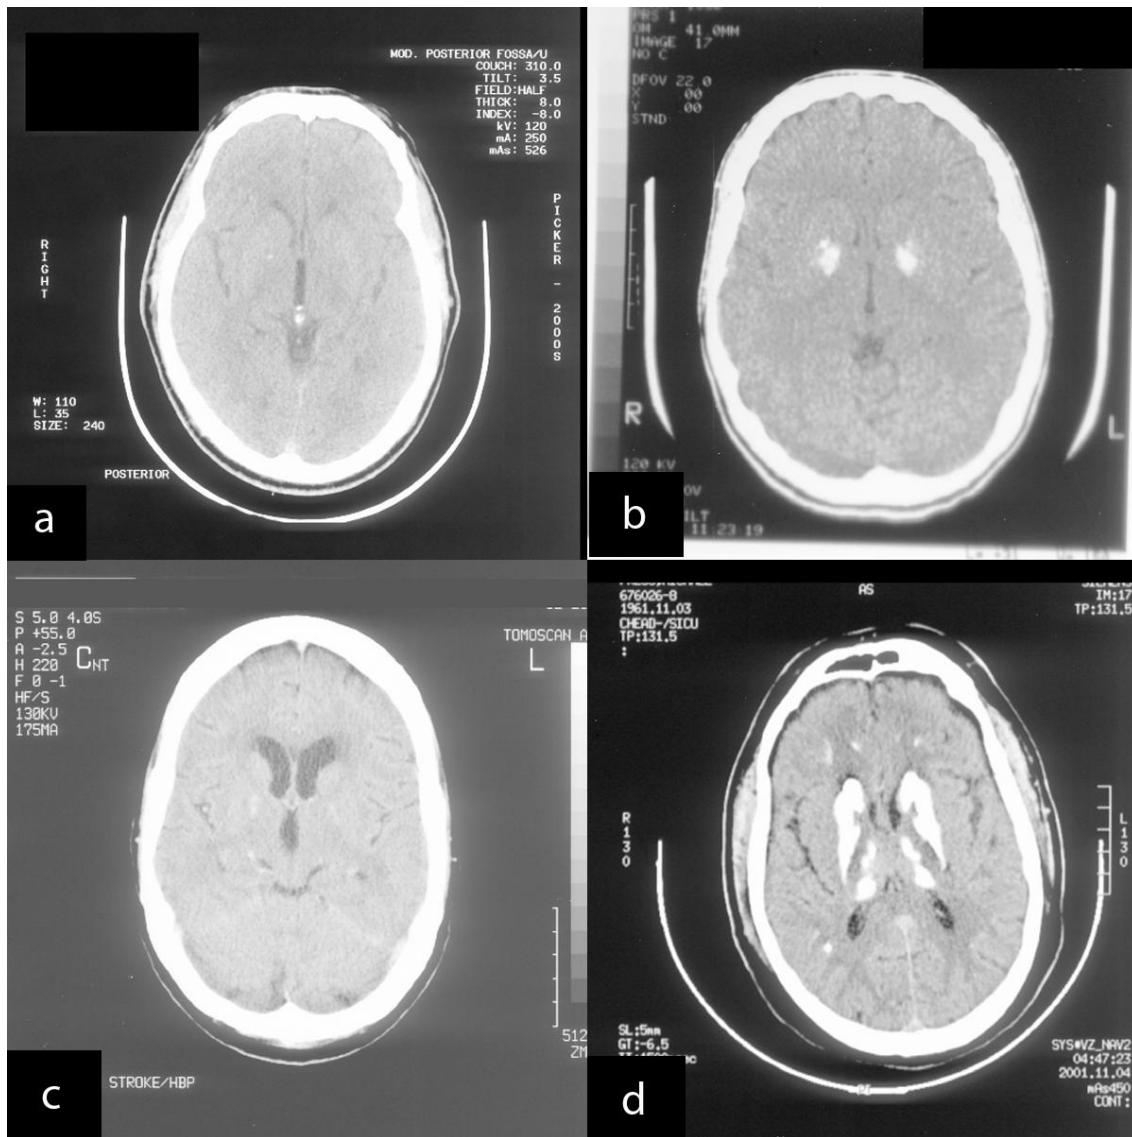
Brain CT images of non-segregating individuals and positive controls
